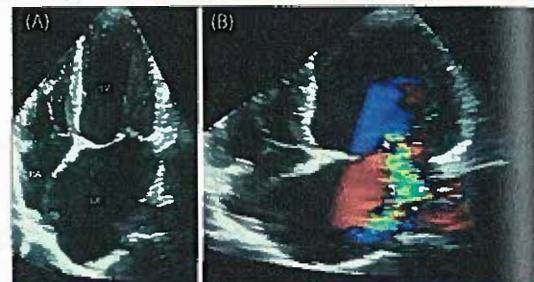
(A) Echocardiography of Mitral Regurgitation with dilated LA and LV, (B) Echocardiography of Mitral Regurgitation
